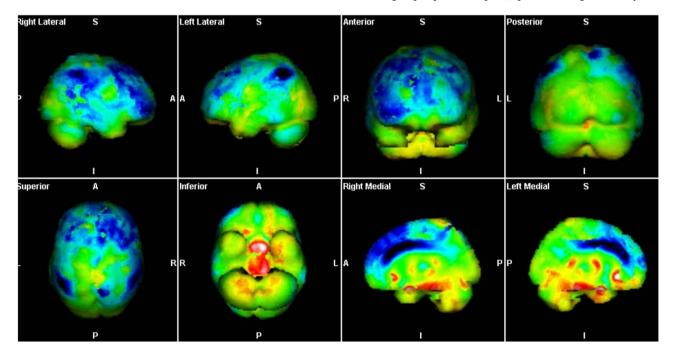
3-Dimensional stereotactic surface projection (3D-SSP) results showing the spatial distribution of FDG hypometabolism in AD – again demonstrating the residual tracer activity on the thalami and basal ganglia.
